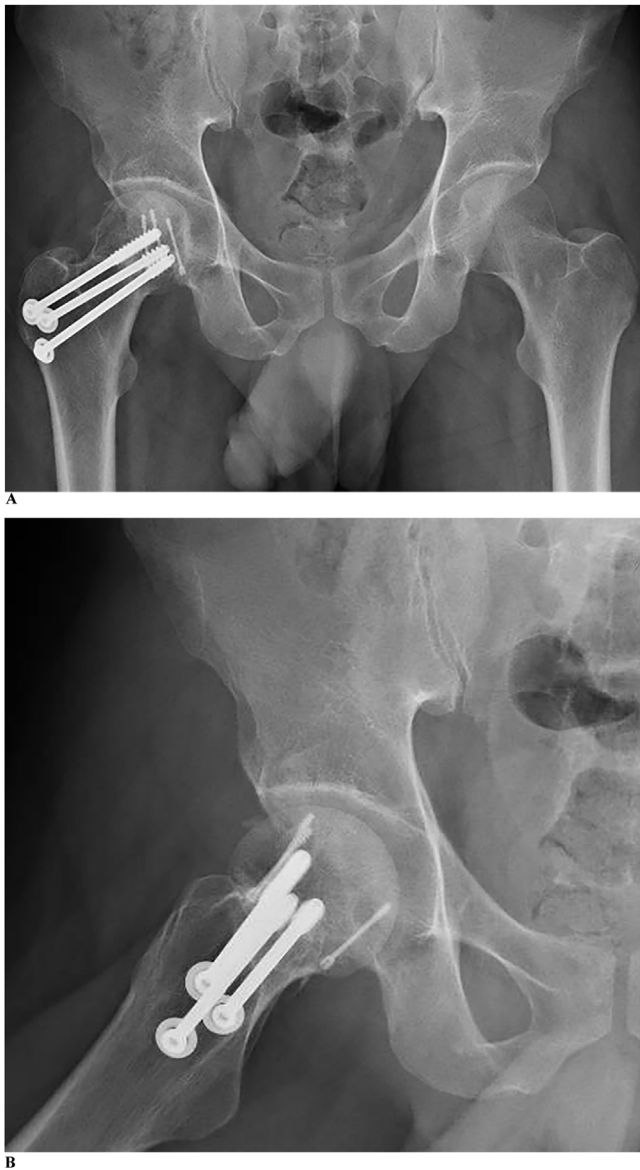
A. Anteroposterior radiograph of the pelvis at 26 months postoperatively. B. Lateral radiograph of the right hip at 26 months postoperatively.
